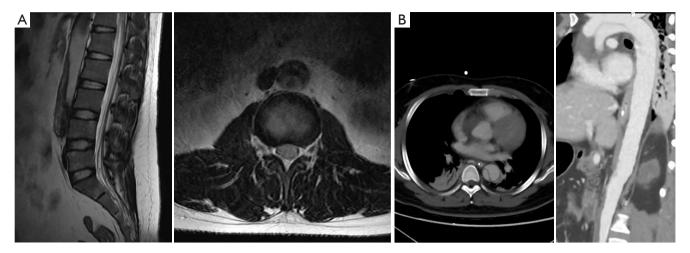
Occult aortic dissection. MRI showed stratification in the descending aorta, with high flow signal in the false lumen and low flow signal in the true lumen in the aorta (A). CT MPR reconstruction showed a double-lumen shadow of the aorta, with both the true and false lumen being filled with contrast agent (B). MRI, magnetic resonance imaging; CT MPR, computed tomography multiple planar reformation.
